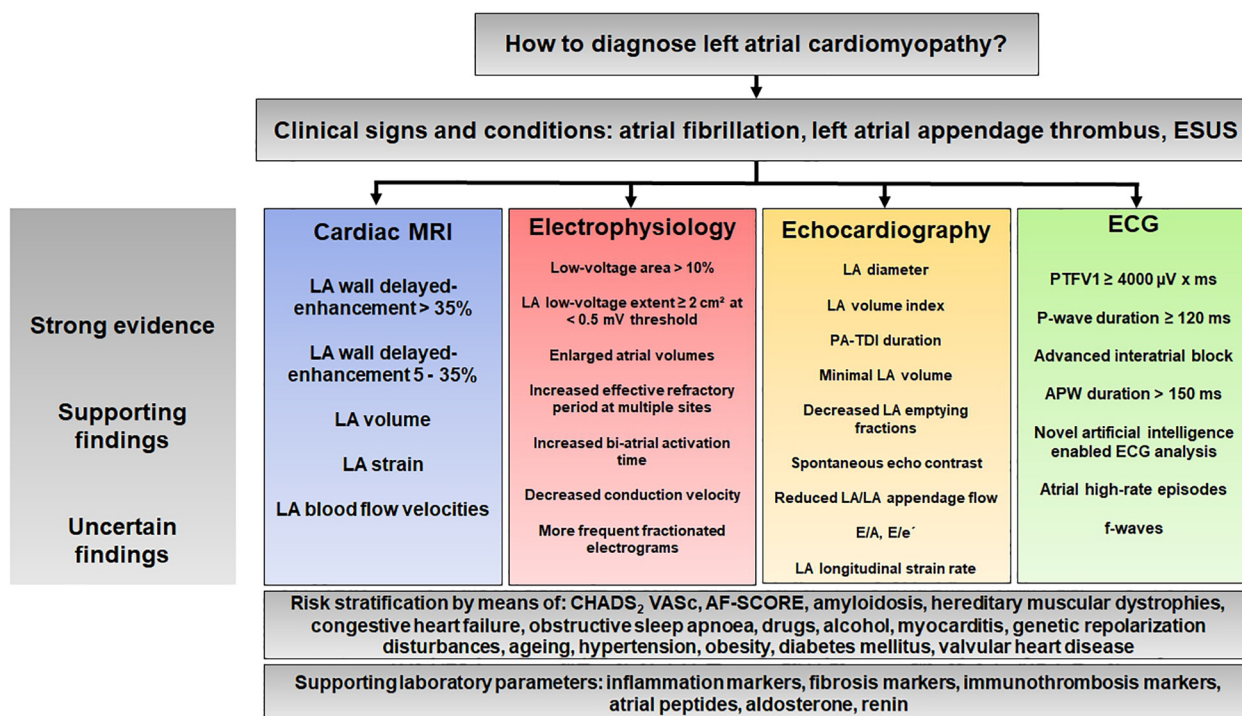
Proposal for a diagnostic algorithm for atrial cardiomyopathy based on the results of previous studies. APW, amplified P-wave; ESUS, embolic stroke of undetermined source; LA, left atrium/left atrial; PA-TDI, total atrial conduction time assessed by tissue doppler imaging; PTFV1; P-wave terminal force in lead V1.
